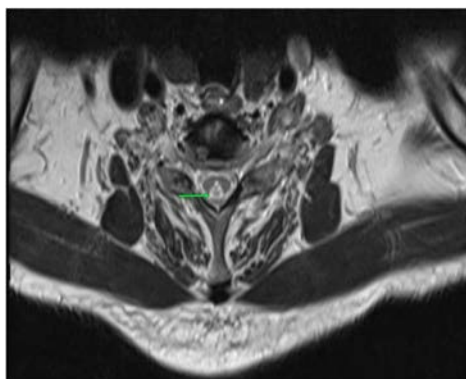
Axial T2-weighted MRI at the level of the cervical cord demonstrating bilateral symmetric dorsal column hyperintensity producing the inverted V sign (green arrow).
